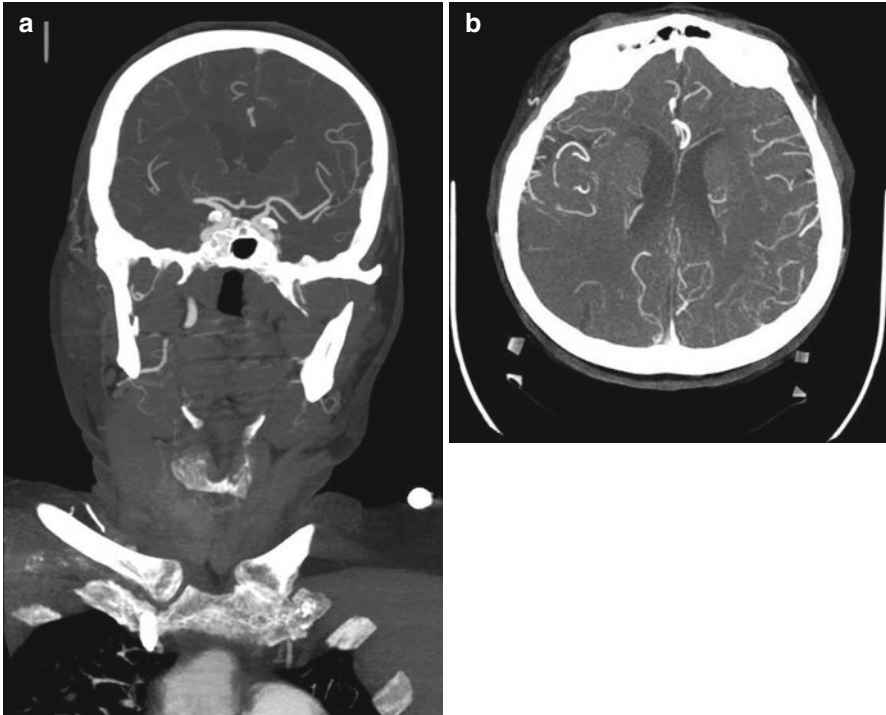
CT Angiogram. (a) Coronal section showing an occlusion of the right MCA. (b) Transverse section with hypoattenuation of brain parenchyma of the right parieto-occipital region
